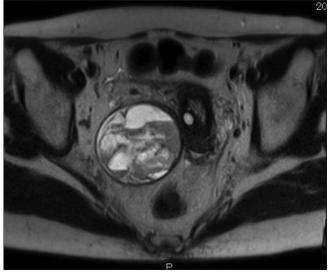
Magnetic resonance imaging image. T2-image: high and low signals in inner cysts
